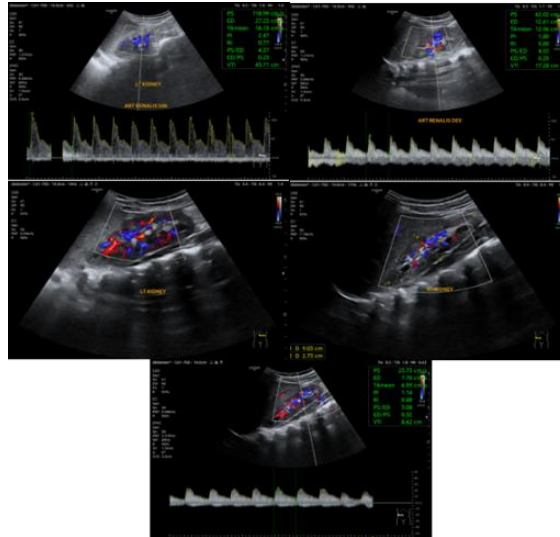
Doppler ultrasound showed suggestive of mild bilateral renal artery stenosis
